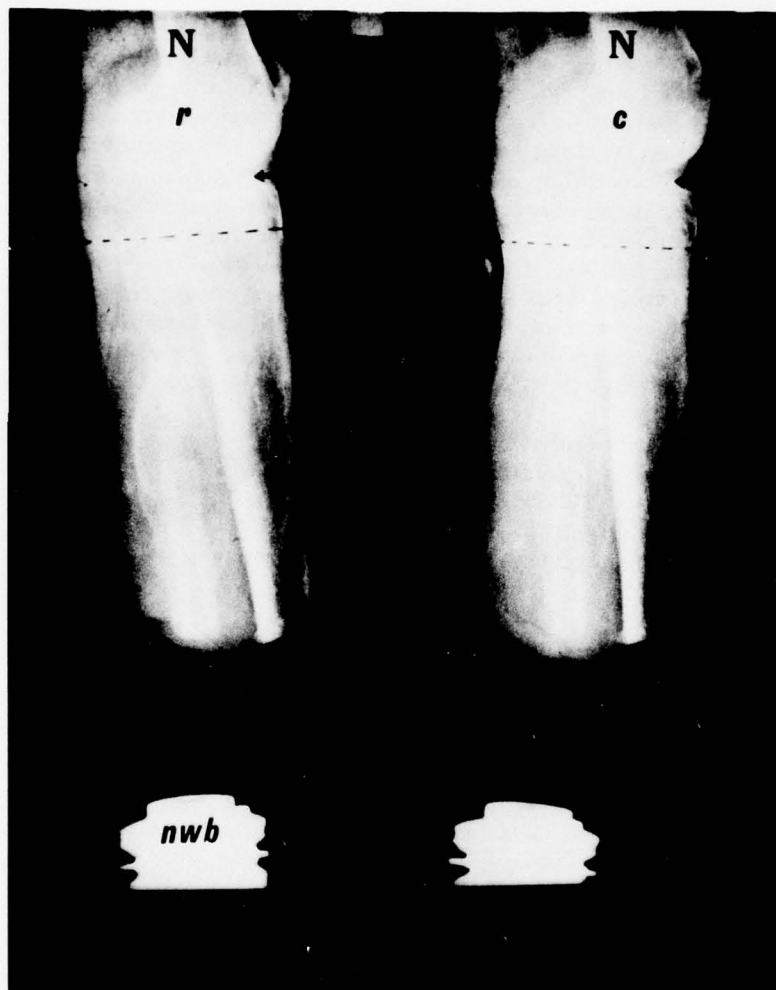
X-ray of patient No. 3's residual limb, showing bony callus at proximal end of fibula.
